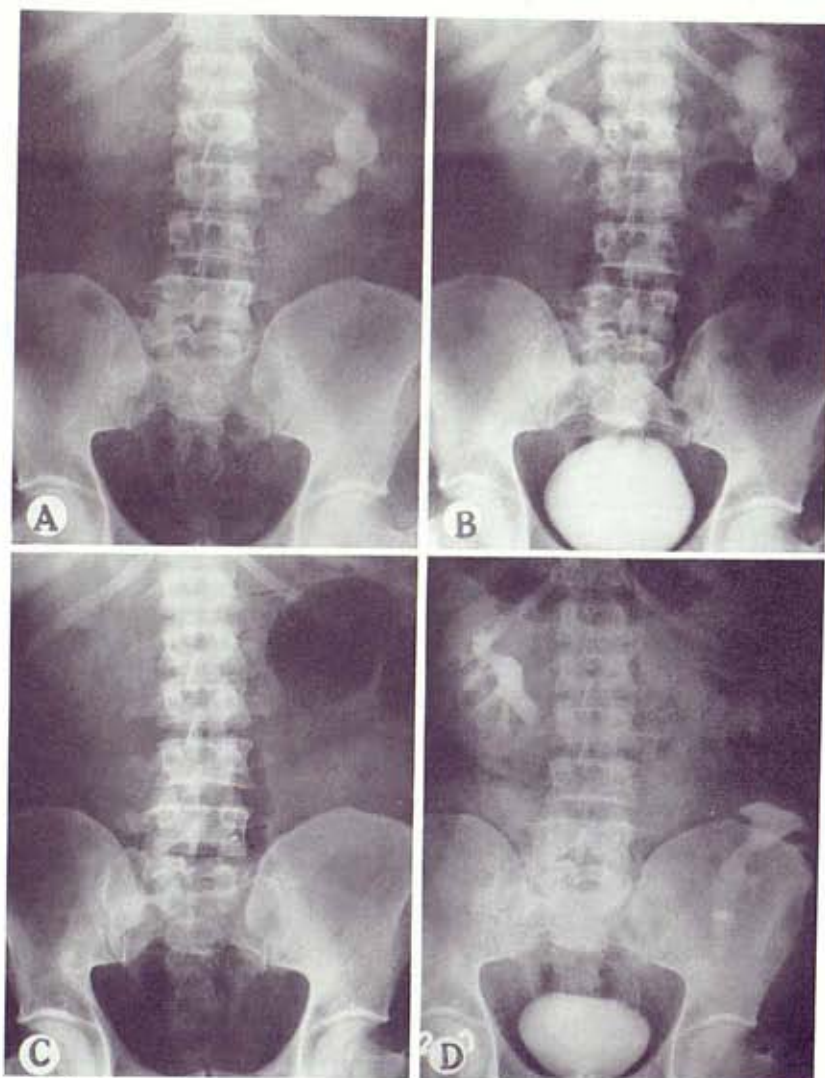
Case 8. *A*, x-ray reveals relapsing staghorn lithiasis in horseshoe kidney of 130 kg. patient. *B*, preoperative IVP reveals malfunction of left kidney, carrier of urocutaneous fistula. *C*, postoperative x-ray shows complete removal of staghorn calculus. *D*, postoperative IVP.
